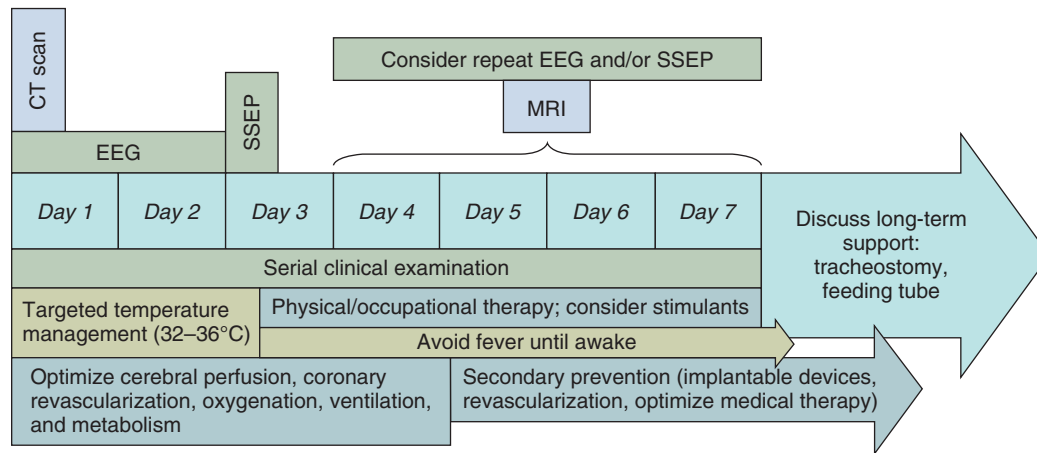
■ Rational approach to neurologic treatment, monitoring, and testing after cardiac arrest. For patients remaining in coma, hypothermia treatment followed by therapy and stimulation may improve recovery. Early electroencephalogram (EEG) monitoring is recommended not for prognosis but to allow detection and treatment of seizures. Absence of cortical response on somatosensory evoked potential (SSEP) or malignant EEG patterns after hypothermia treatment may help identify subsets of patients unlikely to ever show improvement. When those tests are indeterminate, and there is no sign of clinical improvement, magnetic resonance imaging (MRI) of the brain may help quantify extent and location of injury, which in turn assists in decisions about continuing long-term support. Most tests are not required when patients exhibit clear clinical improvement. Conversely, patients who progress to brain death should undergo brain death testing once toxicologic confounds, metabolic abnormalities, and shock have been corrected.
